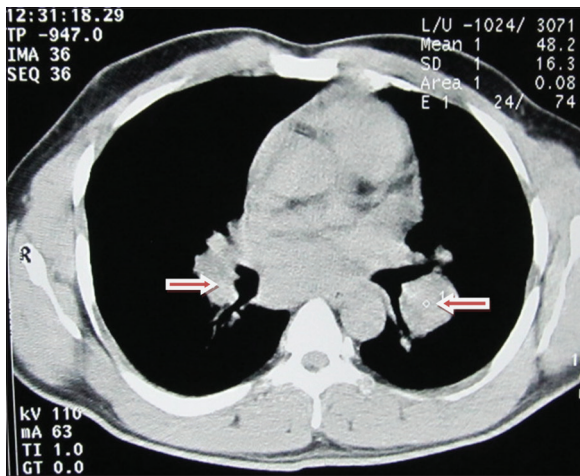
Computed tomography chest showing bilateral hilar adenopathy (arrows) – "Potato nodes" appearance
